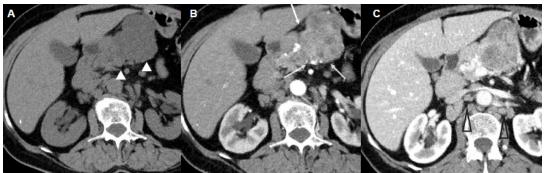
CT of serous cystoadenoma of the pancreas
